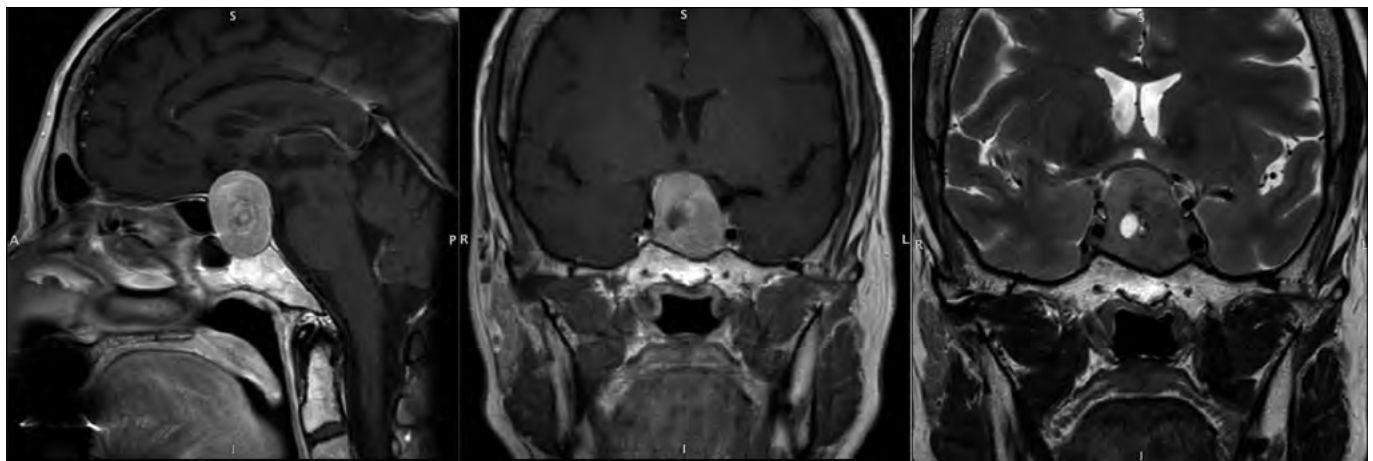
Sagittal and coronal MRI T1 with gadolinium and coronal T2 views showing a macroadenoma stretching upward the optic chiasm.
